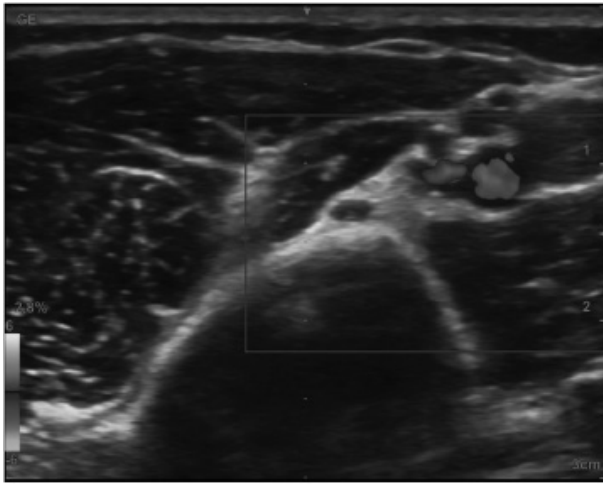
Doppler ultrasound facilitates the visualization of the arteries and veins which are often in proximity of larger nerves. The musculocutaneous nerve is to the left of the blood vessels in the arm.
